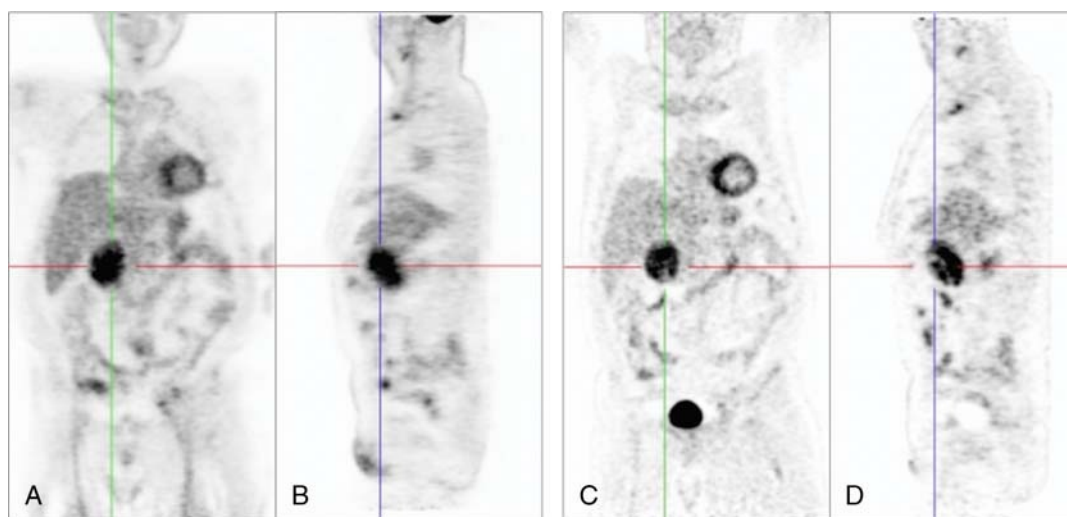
Coronal and sagittal maximum intensity projections of the same patient shown in Figure 2, based on the PET data obtained from ^{18}F -FDG PET/MR (A and B) and ^{18}F -FDG PET/CT (C and D). The duodenal lymphoma manifestations in the centers of the crosshairs show high ^{18}F -FDG uptake on all images.
